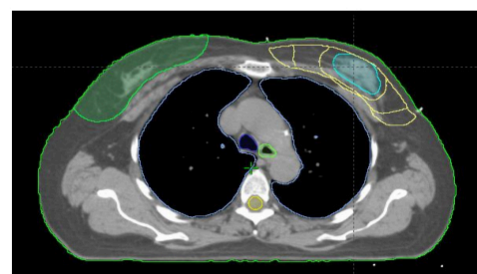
PTVs cropped from external contour on original CT
